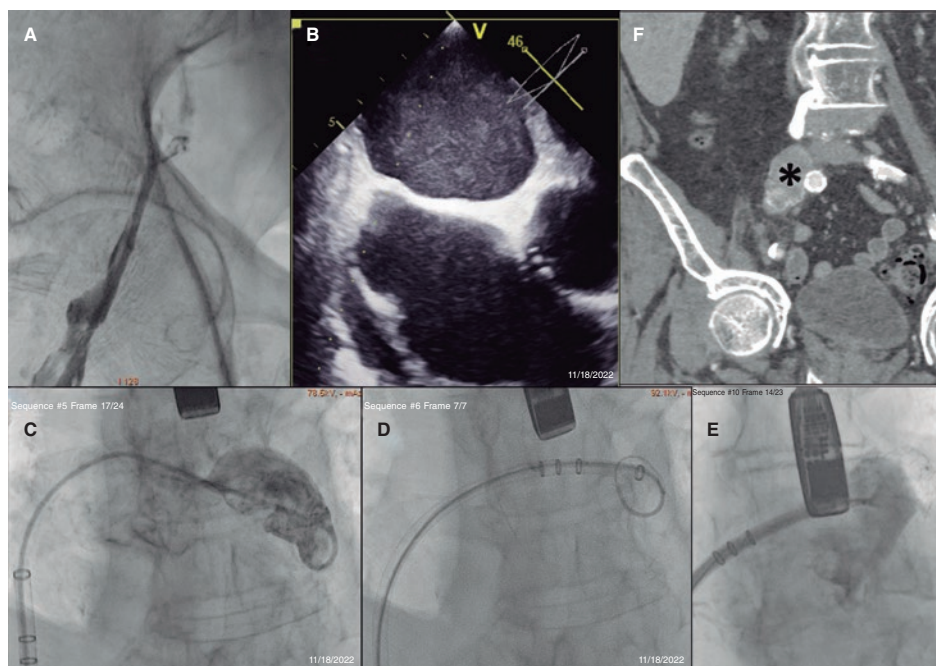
Venography reveals the presence of a complete obstruction that triggered change to left access route (A). Note the unusual position and limited support of both the transseptal puncture needle (B) and the delivery catheter (C). The increased support provided by the rigid guidewire to the 6-Fr pigtail catheter facilitated sheath placement and device release (D, E). The CT scan (F) revealed the presence of an oversized right common iliac vein with hyperdensities inside.
